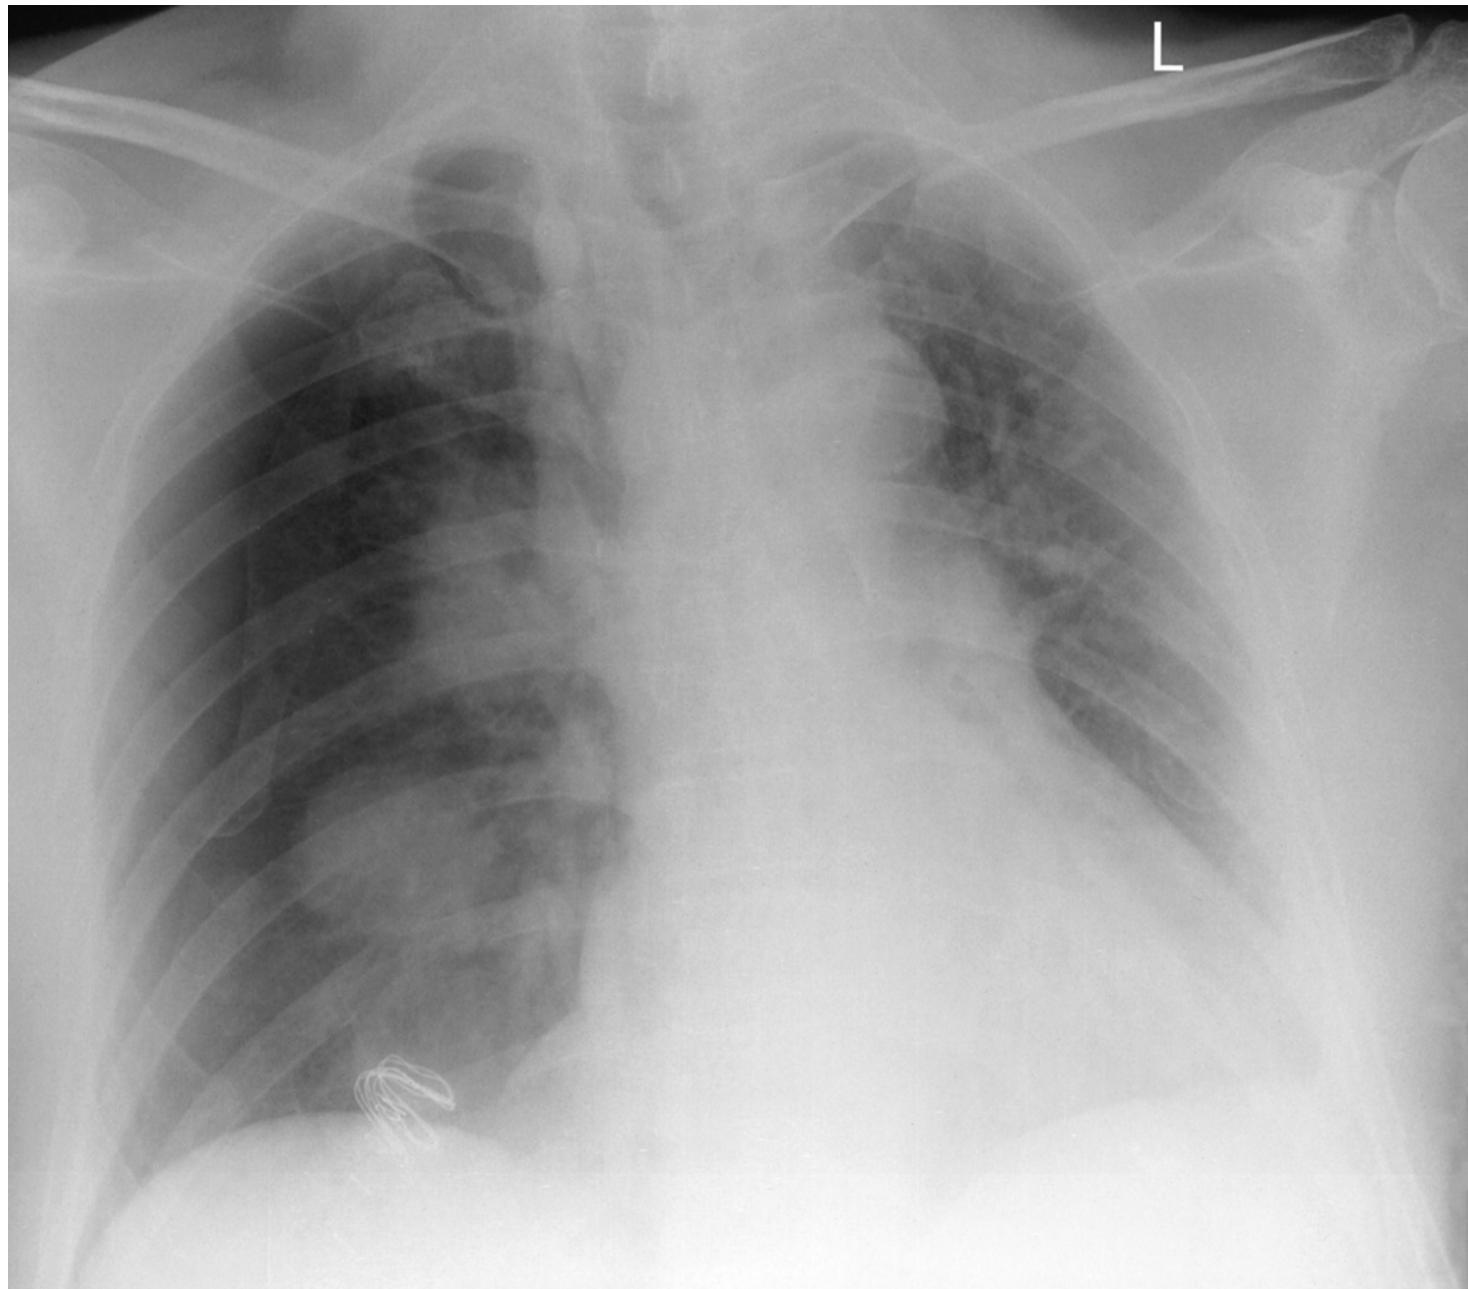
Postoperative supine chest radiograph following right nephrectomy for tumor.
